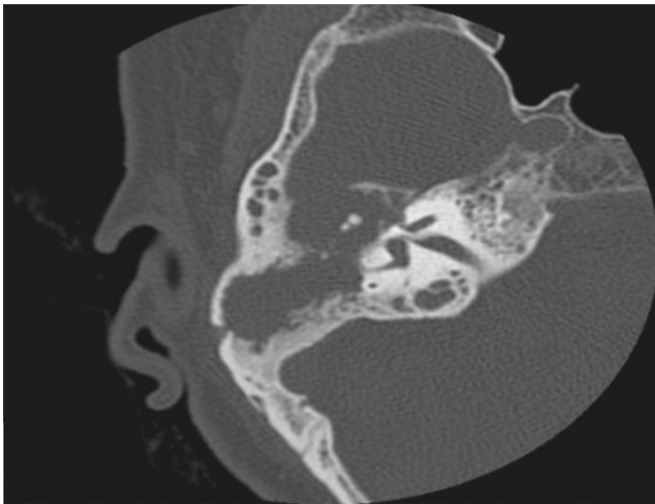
HRCT Temporal bone, Axial cut : Erosion of lateral SSSC, lateral cortex of mastoid, dehiscent tympanic segment facial nerve, ill defined anterior wall middle ear.
